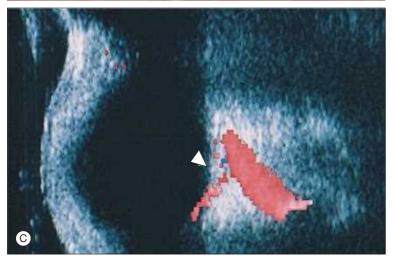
Exophthalmos. (A) A 60-year-old female patient, who has left chronic "red eye." (B) Corkscrew (arterialized) vessels caused by low-flow (carotid–cavernous sinus) fistula. (C) Color Doppler image that shows impedance and reversal of flow in superior orbital vein (*arrow*). (B, Courtesy Dr. Christopher Kelley, Wills Eye Hospital.)
